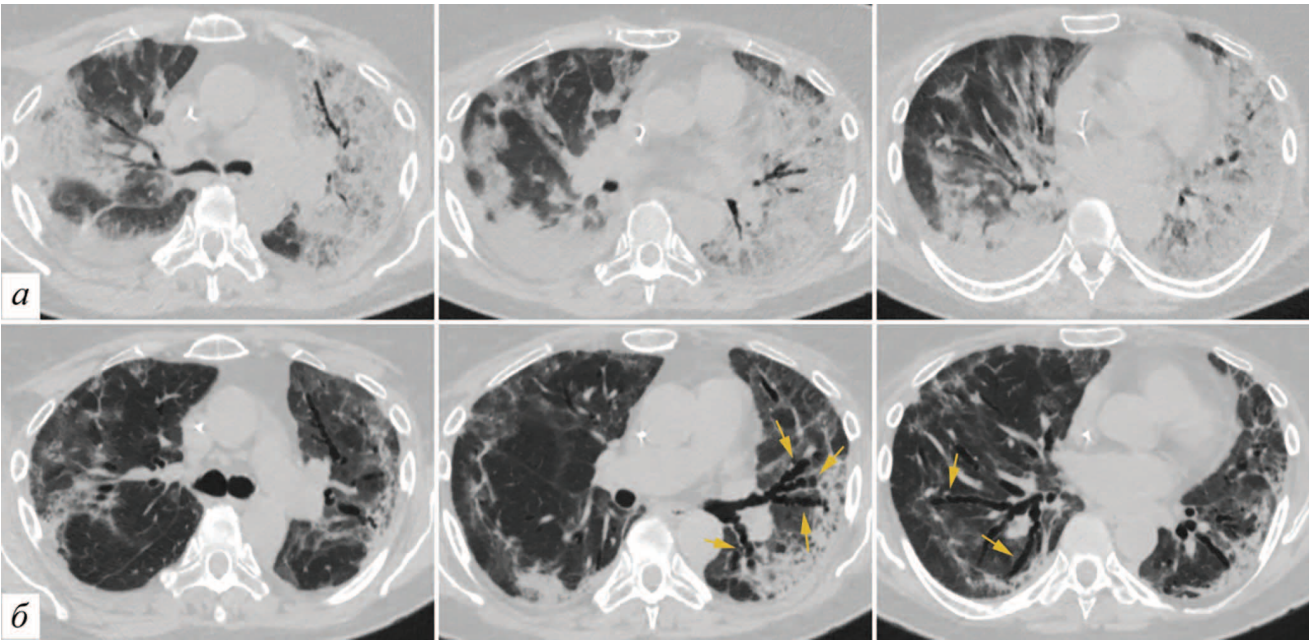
Patient A., 74 years old. COVID-19 (PCR+). Thoracic CT scans in the axial projection. Row a — study dated 03/25/2021 and row b — study dated 04/19/2021 at the corresponding levels, taking into account different depths of inspiration. Top (a) — CT picture of acute viral damage with a lesion volume of at least 75 %. Below (b) — dynamics at the stage of resolution, the appearance of deformation and expansion of the lumens of large bronchi, especially in the lower parts of the lungs (arrows)
